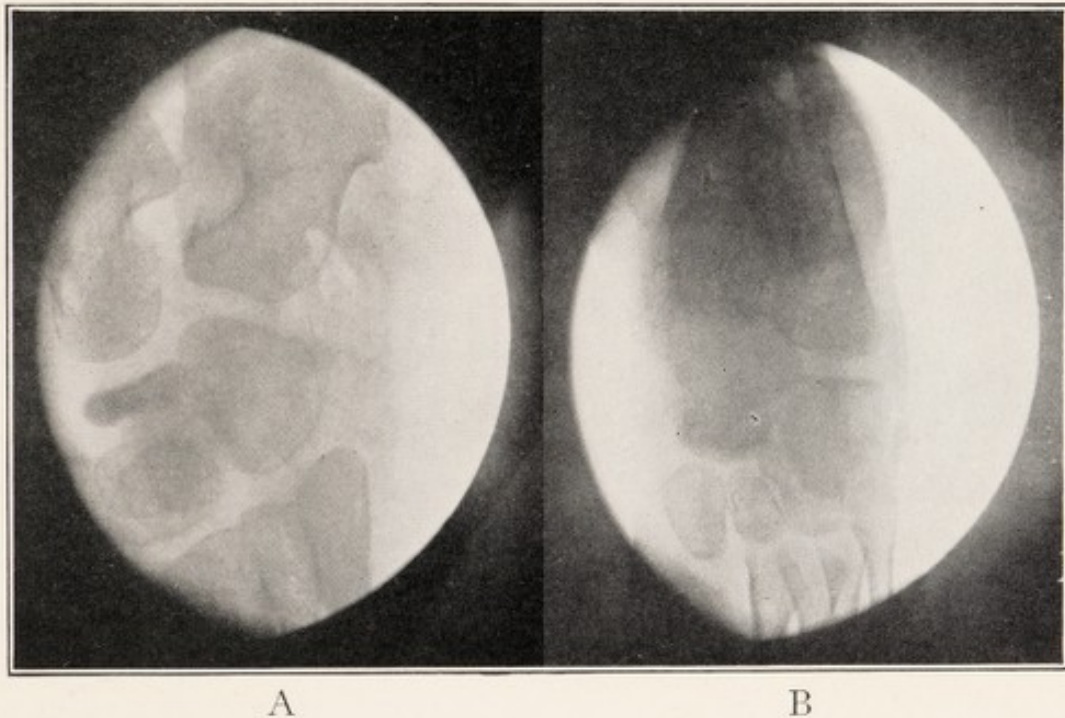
X-RAY SHOWING OSTEITIS OF SCAPHOID, ANTEROPOSTERIOR VIEW.
